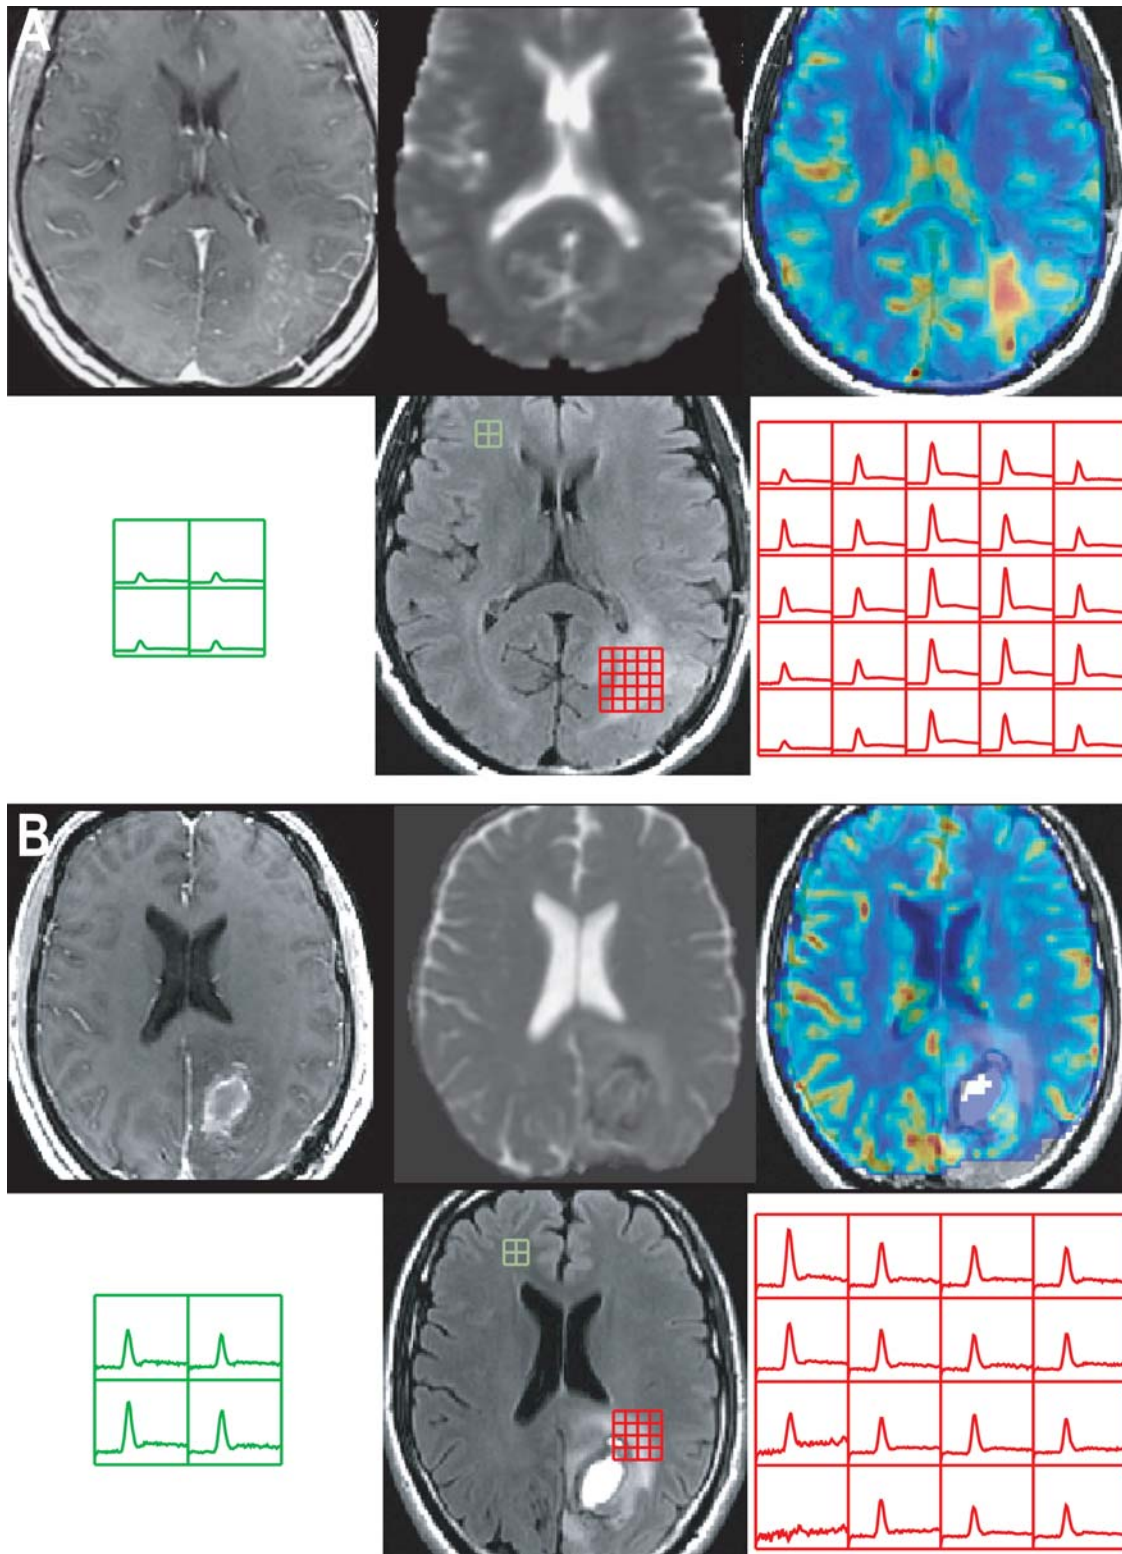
Postcontrast T1-weighted, T2-weighted, ADC, nCBV, and nPH images from 2 patients with GBM and the corresponding $\Delta R2^*$ curves showing the magnitude of PH and Rec parameters in the T2ALL and NAWM regions at pre-RT. All the nCBV and nPH maps were plotted with the range between 0 and 5. Patient A had a short PFS of 128 days, and Patient B was stable at 378 days.
